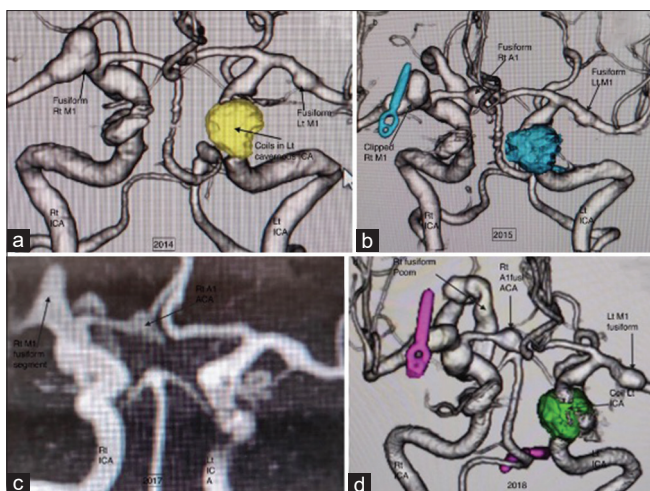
(a) 2014 computed tomography angiography anteroposterior view showing coiling in left cavernous internal carotid artery segment and fusiform aneurysm in the right and left M1 middle cerebral artery segment. (b) In 2015 new fusiform aneurysm segment in right A1 anterior cerebral artery. (c) Magnetic resonance imaging angiography in 2017 showing further progression in size of right M1 middle cerebral artery fusiform segment. (d) 2018 computed tomography angiography showing further progression in the fusiform segment of left M1 middle cerebral artery, right internal carotid artery, right posterior communicating artery, and P2 posterior cerebral artery
